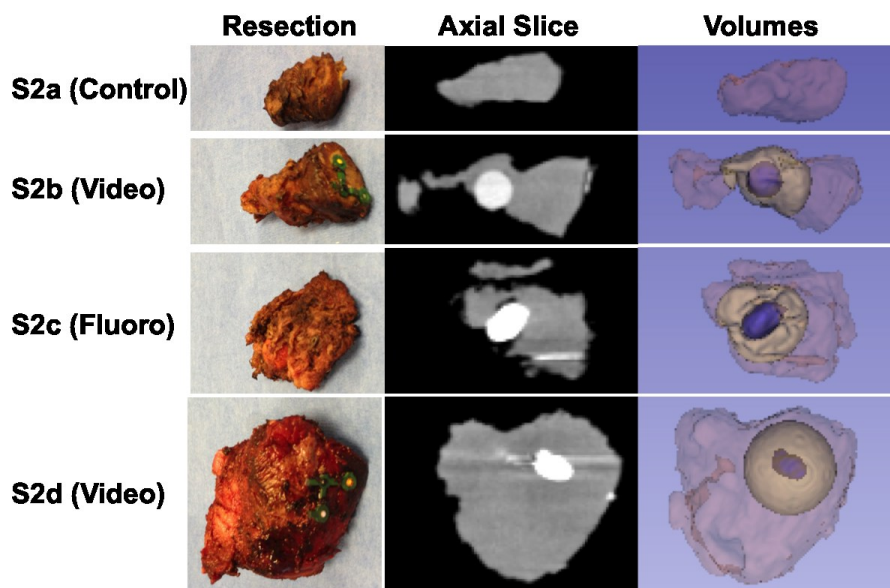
Resected tumor and margins with corresponding slices (tumor in high intensity, white) and segmented volumes (tumor in blue, intersection with ideal margin in yellow) from postoperative CBCT.
